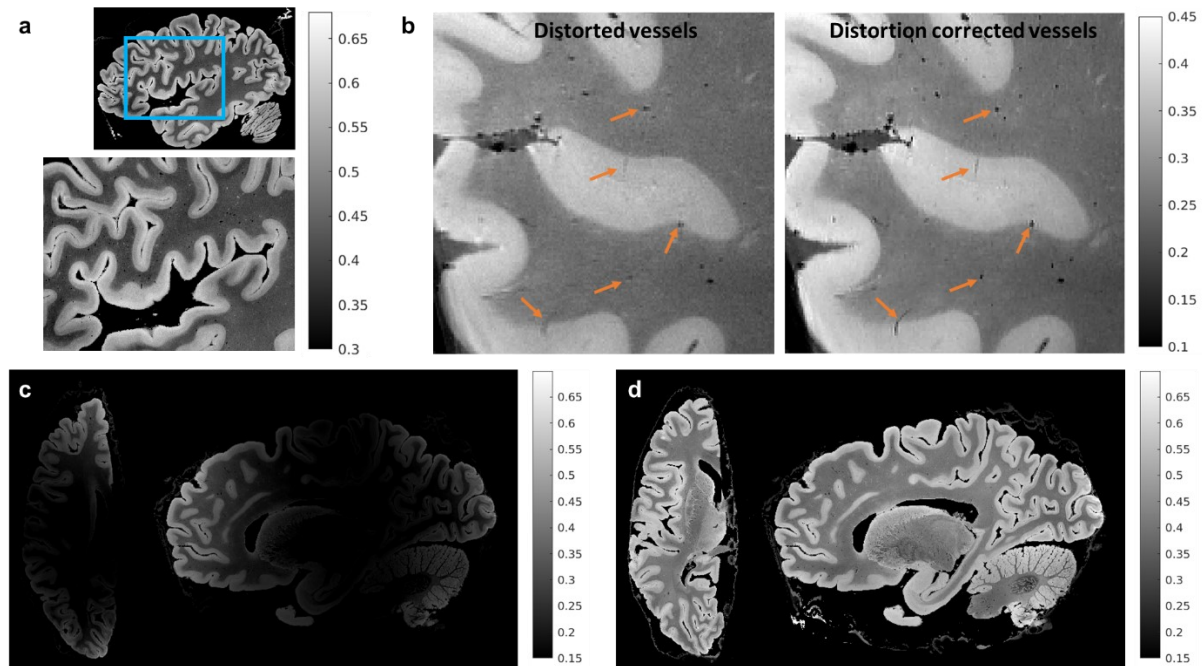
MRI for global reference. The figure shows results for 150 μm isotropic root mean squared (RMS) FLASH MR images with RMS calculated across four echo times ($\text{TE} = 5.65, 11.95, 18.25$ and 24.55 ms) for a flip angle of 20° . a) A sagittal section that is zoomed into the Broca's area showing infra- and supra-granular gray matter contrast. b) A zoomed-in sagittal frontal section of the same brain sample with vessels that are blurred and have reduced contrast. The blurring is due to B_0 field inhomogeneity while the reduced contrast is due to B_1 transmit field inhomogeneity. We also show vessels post-distortion correction that are well preserved and have high contrast, demonstrating the effectiveness of the correction methods. c) and d) show an axial and sagittal slice before and after B_1 receive intensity bias correction. The intensities are visibly more uniform after bias removal.
